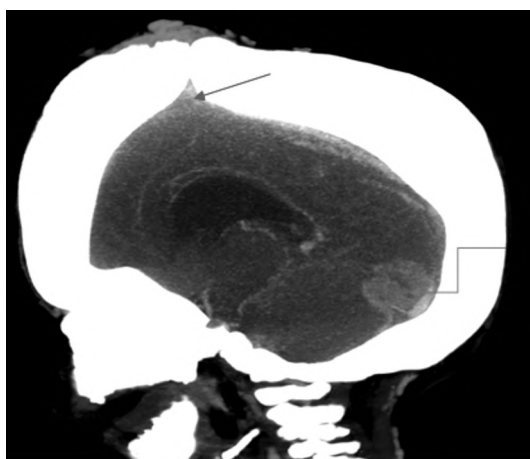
Skull CT scan showing upward protrusion of the brain parenchyma into the anterior fontanelle (red arrow), and intracranial hematopoiesis (blue arrow). Also note the thickened skull bone.
